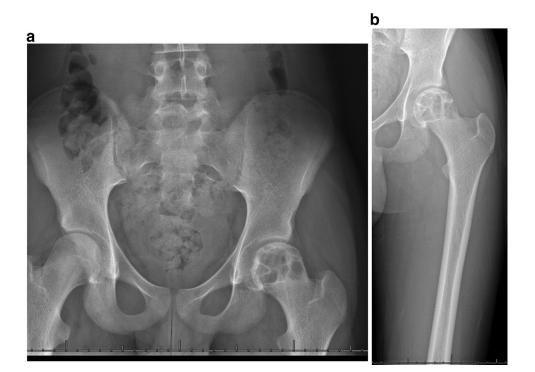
Skeletal survey study, here depicting a pelvis AP (A) and femur AP (B) radiograph demonstrating a multilocular cystic lesion involving the proximal left femur epiphysis with internal septations noted.
